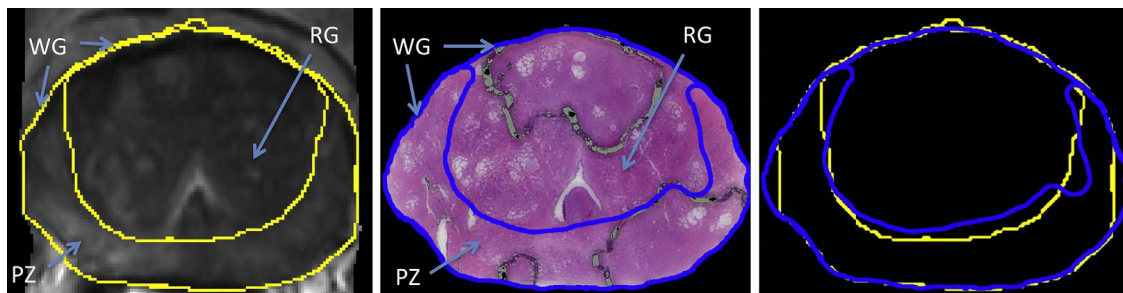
Manual segmentations of the WG and PZ as well as the RG for patient no. 8. in one of the MRI slices (left), in the corresponding WM section (middle), including overlap of the masks after registration (right).
